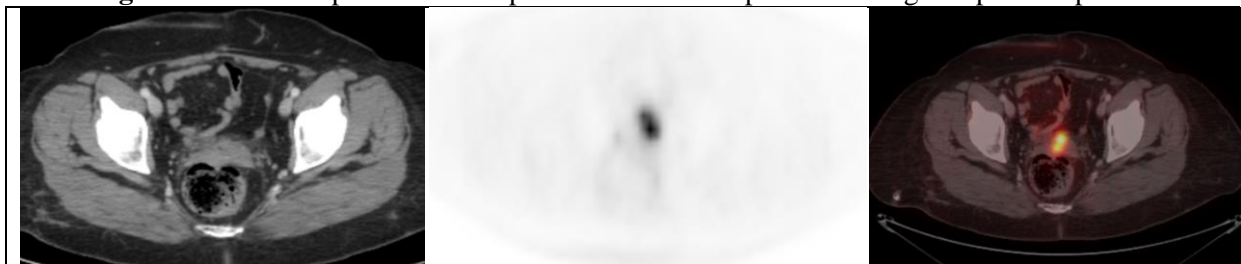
CT, PET & PET/CT images showed operative bed abnormal FDG uptake of about 11.3 SUV max.
